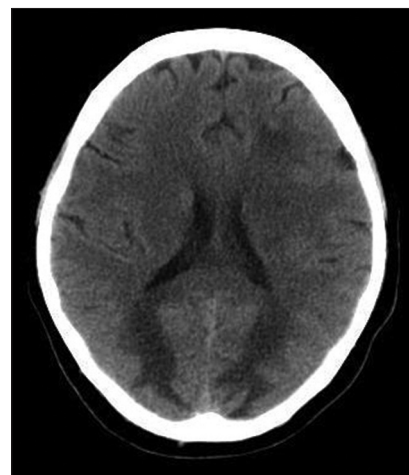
Multislice computed tomography finding in a 35-year old woman at the clinical onset
